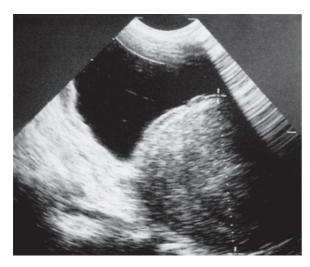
Ultrasound of bladder with RMS of the base of the bladder
